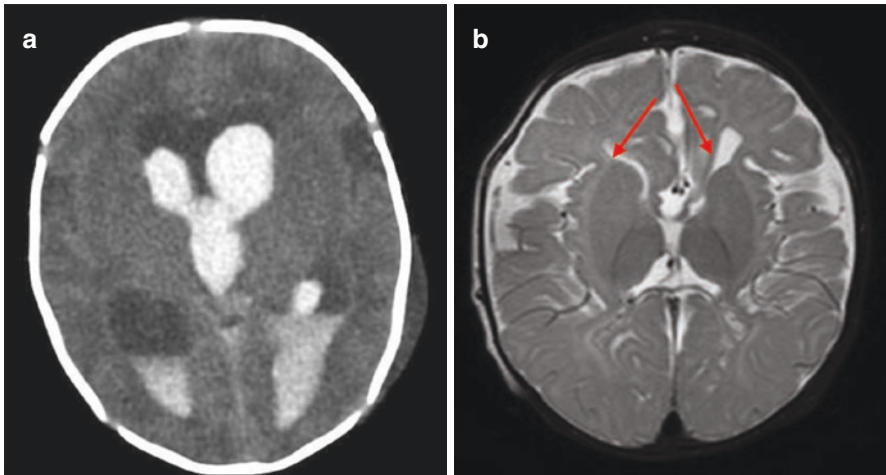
Both brain scans are from the same patient. Image (a) is a CT scan of the patient at 3 weeks of age with significant intraventricular hemorrhage (white fluid in the ventricles is blood) and hydrocephalus of the lateral ventricles. Image (b) is an MRI, T2 sequence, at 9 months of age after VP shunt was placed. The image shows marked reduction in ventricular size (red arrows)
